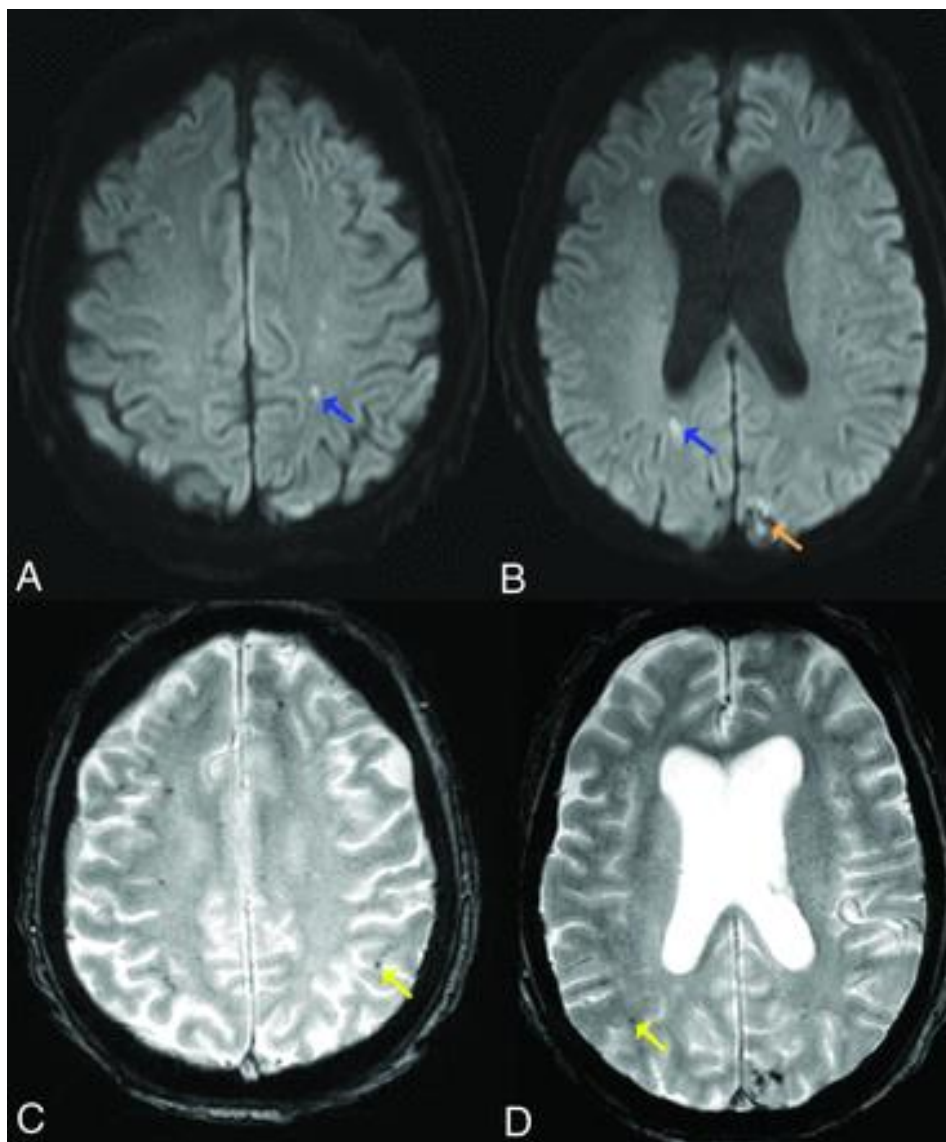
Axial CT (A,B) and gradient-echo scan (C, D) of 61-year-old man with Covid-19. The blue arrows reveal localised region of dead tissue in the cerebral white matter whereas the orange arrows indicate haemorrhagic and dead tissue in the left occipital region. Yellow arrow reveals further haemorrhagic within cerebral hemisphere (Gulko et al., 2020).
